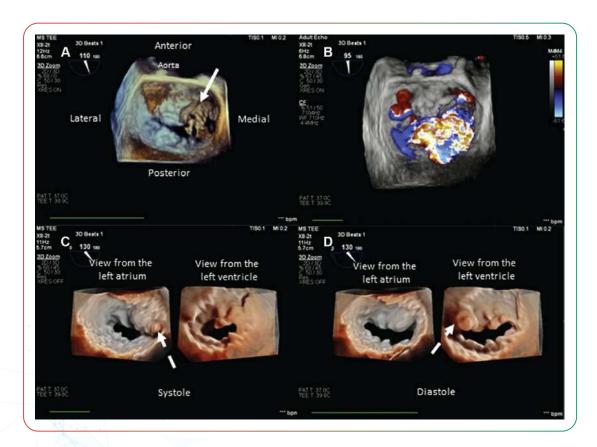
Three-dimensional TEE for view of the mitral valve. (A) The left atrial demonstrates a flail A3 segment with a ruptured posteromedial papillary muscle (arrow) (B) Three-dimensional color Doppler demonstrates severe MR. C& D- Three-dimensional transillumination; left atrial (left) and LV (right) perspective demonstrated.
